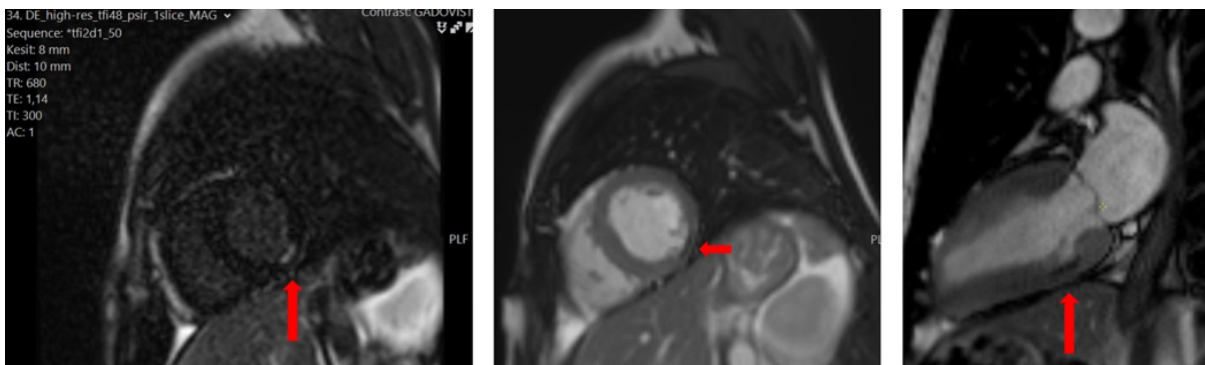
Cardiac magnetic resonance imaging showing inferolateral wall involvement. Red arrows: Areas of delayed gadolinium uptake consistent with myocardial infarction, showing transmural delayed involvement in the inferolateral wall of the left ventricle. Wall thinning and akinetic motion pattern were observed in the same region. These findings correlate highly with calcification foci and wall motion abnormalities observed on CT and echocardiography.
